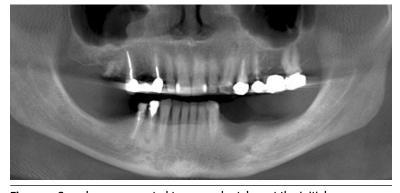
Cone-beam computed tomography taken at the initial consultation. Note the preoperative condition of existing teeth.
